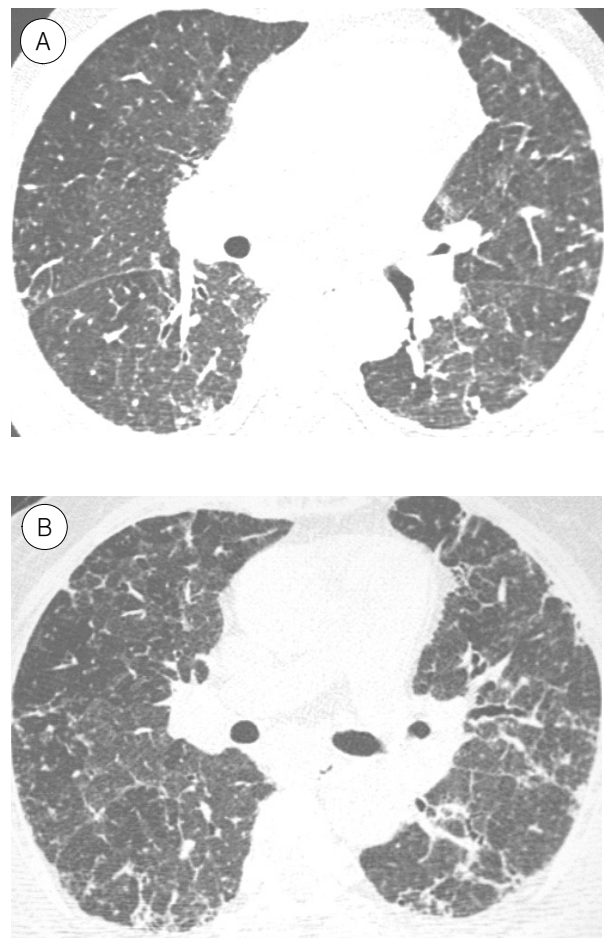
Idiopathic pulmonary fibrosis in a 45-year-old woman. (A) The initial HRCT scan obtained at level of bronchus intermedius shows subpleural reticular opacities and subtle areas of ground glass opacity or small consolidation in the periphery of both lower lobes. (B) After 2 years and 6 months, the follow up CT scan obtained at similar level shows progression of reticular opacities in both lower lobes. There are also seen increased extent of subpleural ground glass opacity and small consolidation.
